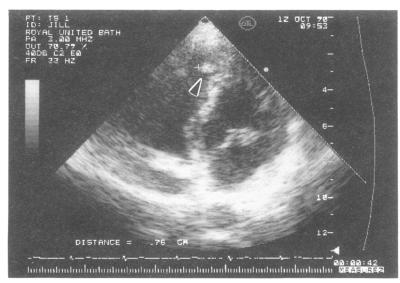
Short axis parasternal view of a parent showing an echodense area in the right ventricle (arrowed).
